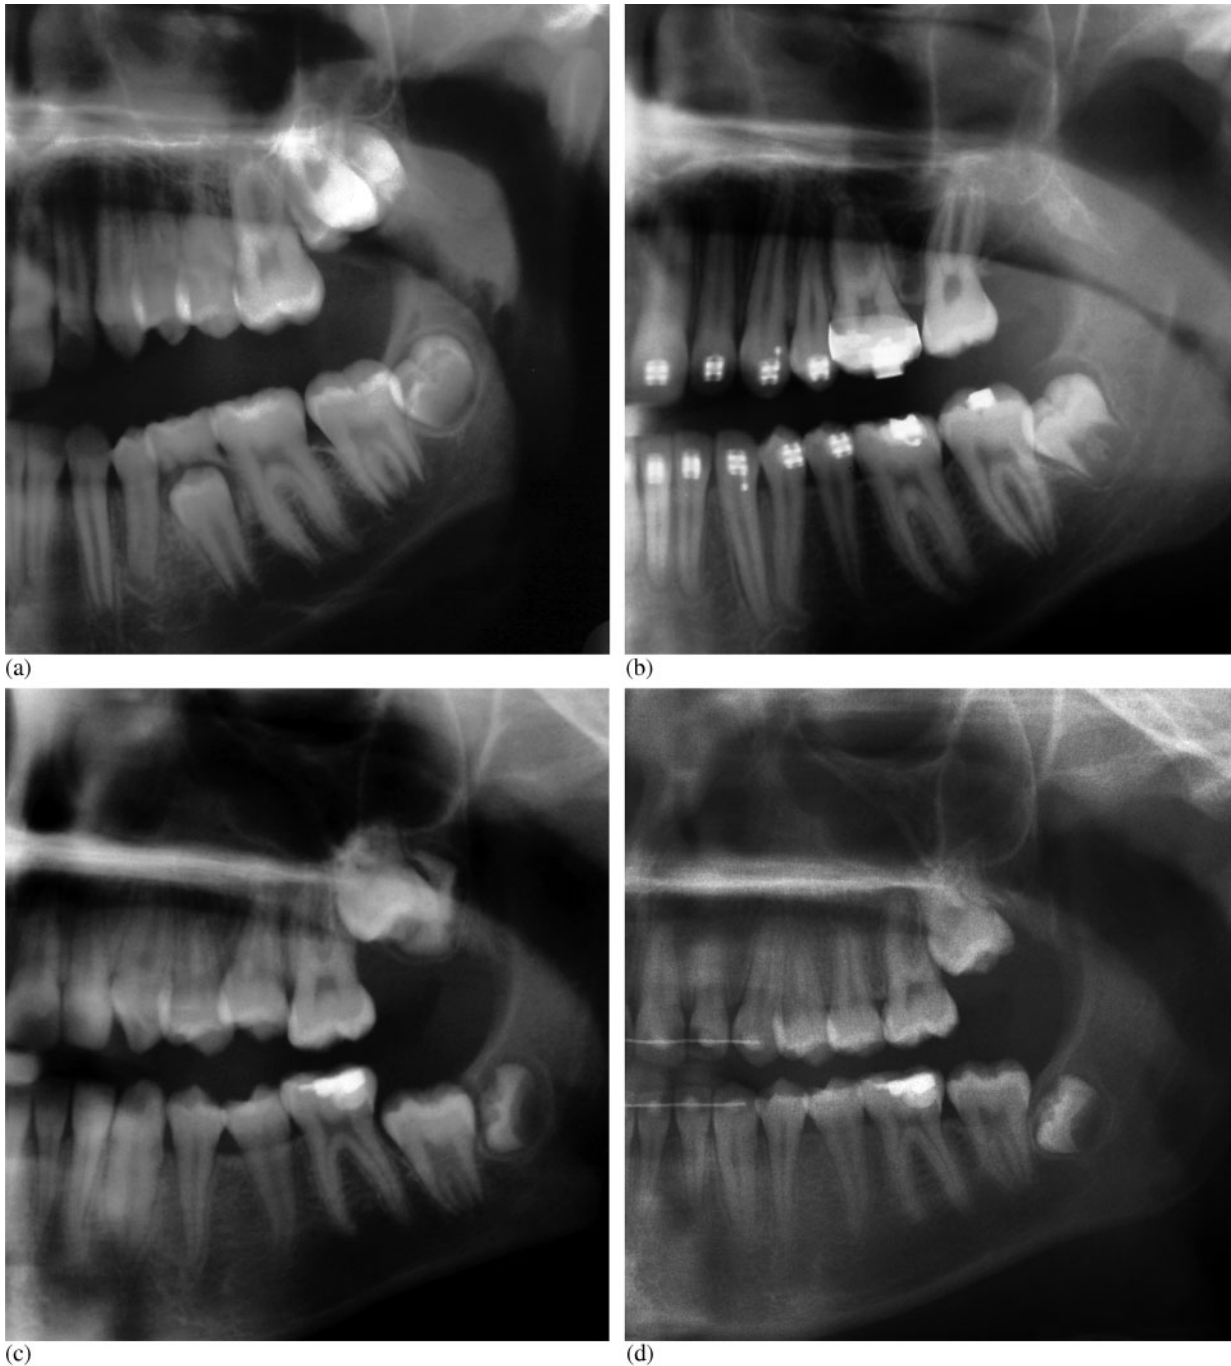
Orthopantomogram of an impacted left upper second molar, before and after surgery: (a,b) category 1 and (c,d) category 3
